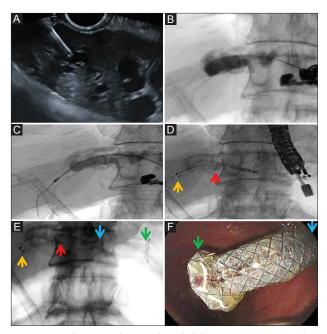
Endoscopic ultrasound-guided hepatico-gastrostomy. (A) Transgastric, transhepatic puncture of a dilated left biliary duct with a 19-G fine-needle aspiration needle under endoscopic ultrasound guidance in a patient with Klatskin tumor and neoplastic ingrowth of previously placed percutaneous metal stents. (B) Contrast injection showing correct biliary access and intrastent neoplastic ingrowth, followed by guidewire cannulation of the biliary duct. (C) Tract creation through a 6-Fr cystotome and guidewire redirected inside the former metal stent. (D) Initial deployment of a partially covered metal stent with the uncovered portion inside the biliary tree and the previous stent, whilst the covered portion is deployed transhepatic and transgastric: yellow arrow, extremity of the stent (uncovered portion); red arrow, transition between uncovered and covered portion of the stent. (E) Final deployment of the stent: yellow arrow, intrabiliary extremity; red arrow, transition between uncovered (endobiliary) and covered (transhepatic) portion; blue arrow, transition between the transhepatic and transgastric portion; green arrow, intragastric extremity with antimigration flange. (F) Endoscopic view of the intragastric end of the hepatico-gastrostomy stent
